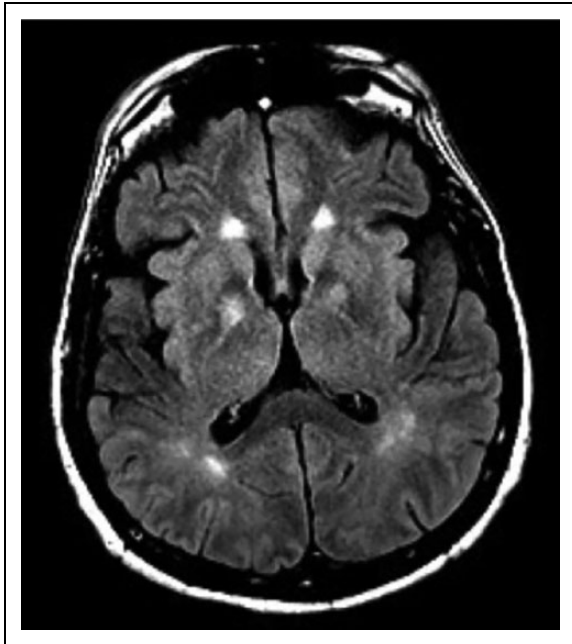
Magnetic resonance imaging (MRI) of the brain T2-Flair sequence of a patient with neuroinvasive West Nile virus (WNV) showing T2-FLAIR hyperintensities of the bilateral globus pallidi. (Courtesy of Dr Shibani Mukerji—MGH Prospective Encephalitis and Meningitis Study [PEMS] cohort).
